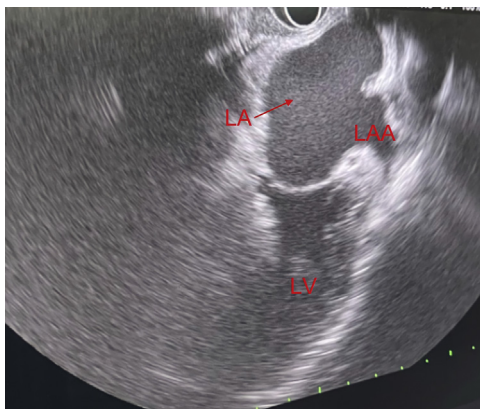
Linear ultrasound image of the left cardiac anatomy. LV, Left ventricle; LA, left atrium; LAA, left atrial appendage.
